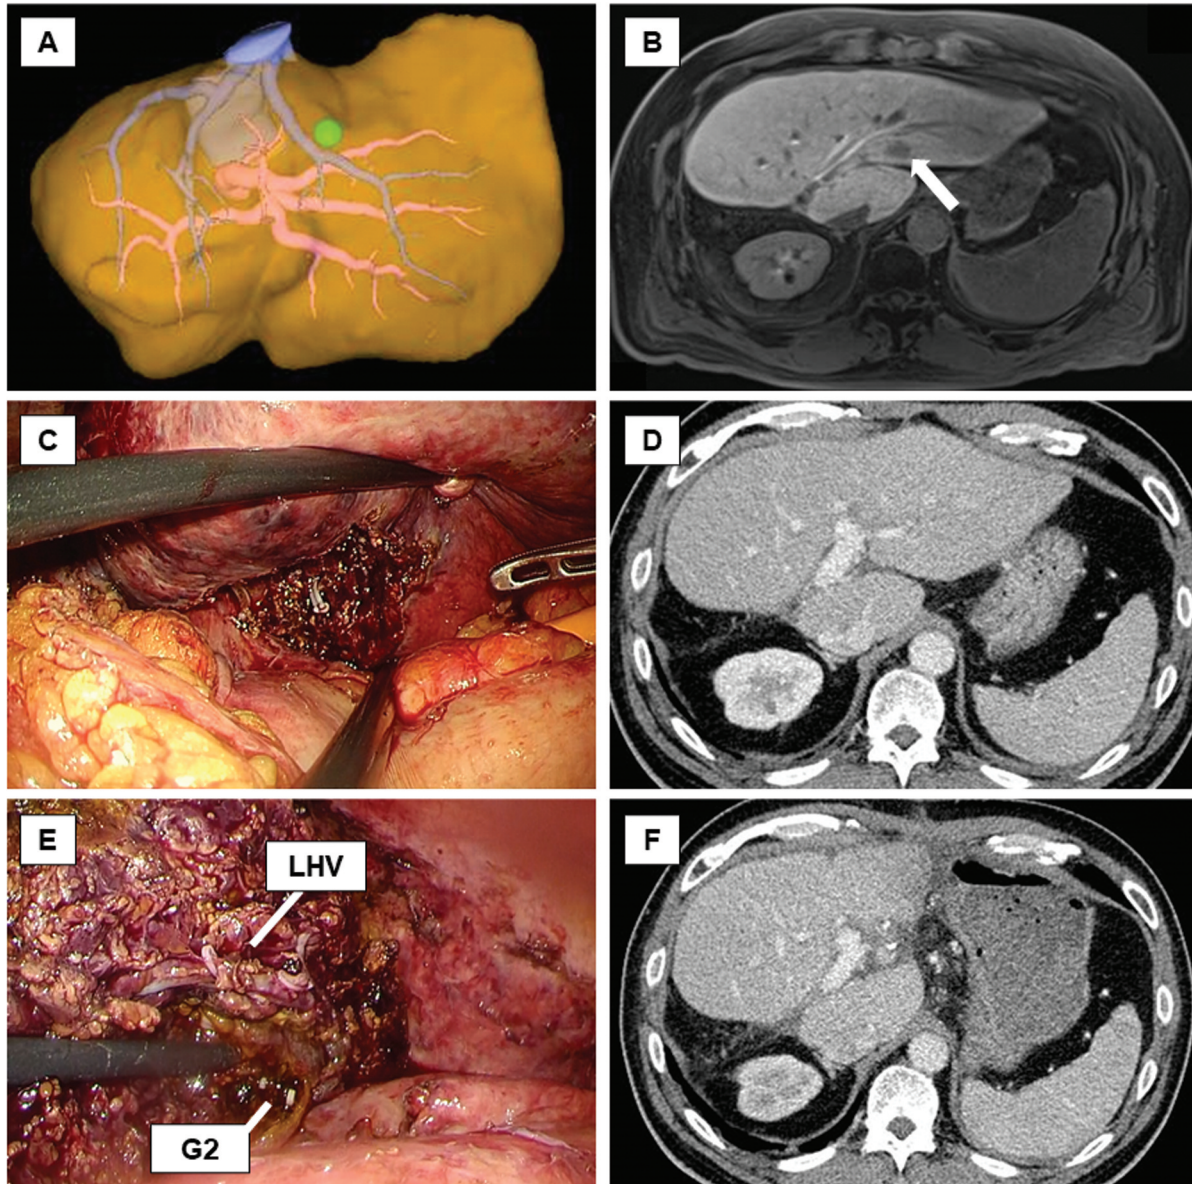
The tumor located in segment 2 on three-dimensional reconstruction (A), and on hepatocyte phase in gadolinium ethoxybenzyl diethylene triaminepentaacetic acid enhanced magnetic resonance imaging (arrow) (B). Glissonean branch of segment 2-oriented partial hepatectomy (C). Postoperative enhanced computed tomography revealed that Glissonean branch of segment 2 was misrecognized with Glissonean branch of segment 3 (D). S2 Sub-segmentectomy (E). Postoperative enhanced computed tomography showed curative resection (F). G2, Glissonean branch of segment 2; LHV, left hepatic vein.
